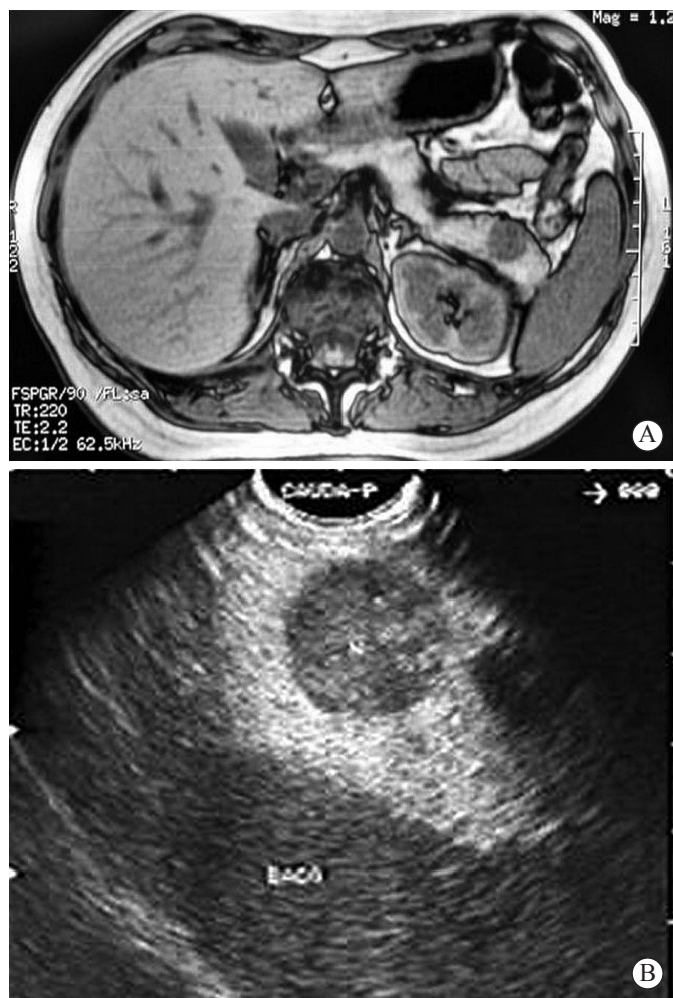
Asymptomatic patient (no. 10) with (a) MRI showing a round, hypointense pancreatic nodule in the pancreatic tail, measuring 1.9 x 1.7 cm. (b) EUS shows a hypoechoic, homogeneous, and regular nodule with well-defined borders. Echogenicity is similar to the spleen. FNA made diagnosis of PS
